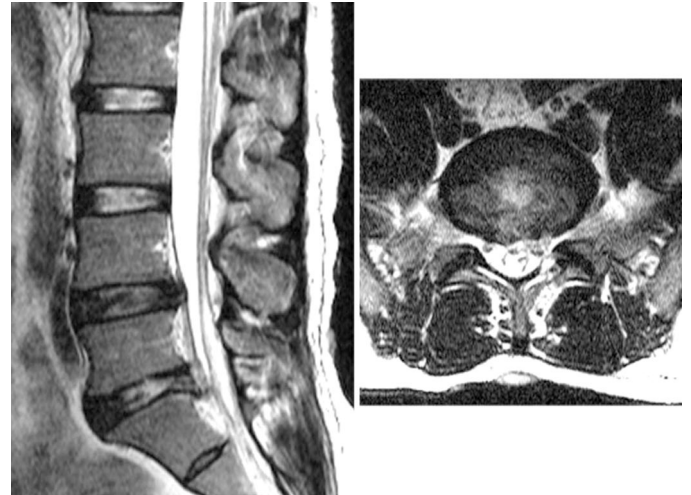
Postoperative MRI scans after interlaminar endoscopic discectomy.
